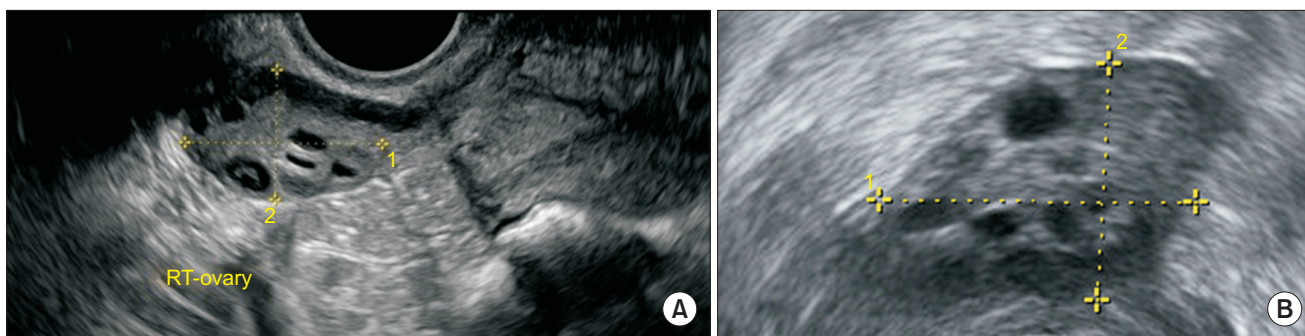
Ultrasound findings of right (RT) ovary in: (A) Case 1; (B) Case 2.
